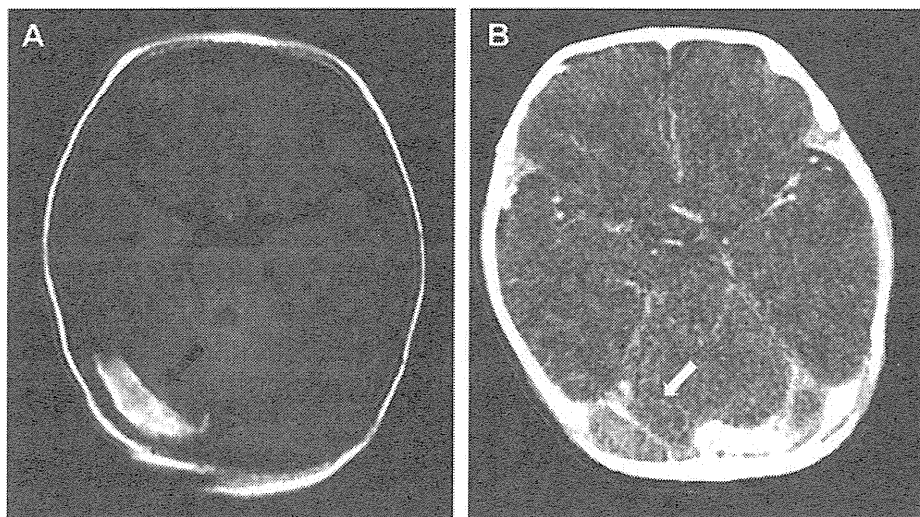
(A) T1-weighted magnetic resonance imaging. (B) Contrast-enhanced computed tomography of the brain after restoration of sinus rhythm. High signal intensity on T1-weighted magnetic resonance imaging (arrow) and flow disturbance on computed tomography (white arrow) confirmed the diagnosis of right transverse sinus thrombosis.
